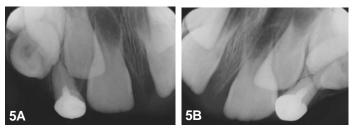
a and b: Periapical radiographs showing complete root canal filling and adaptation of the posts and attachments in teeth 53 and 63, respectively.
